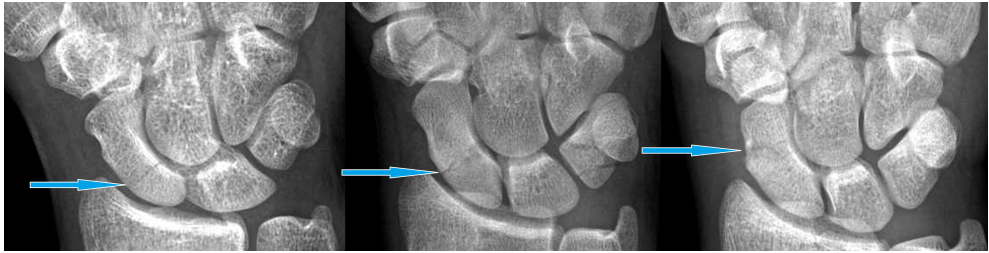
Anterior-posterior radiographs showing scaphoid fractures. Fractures are indicated with an arrow. Left: scaphoid proximal pole fracture, rated as proximal pole by 89% of observers and as a waist fracture by 11%; middle: scaphoid waist fracture where most interobserver variability was seen, rated as proximal pole by 23% of observers and as waist fracture by 77%; right: scaphoid waist fracture, rated as scaphoid waist fracture by all observers.
